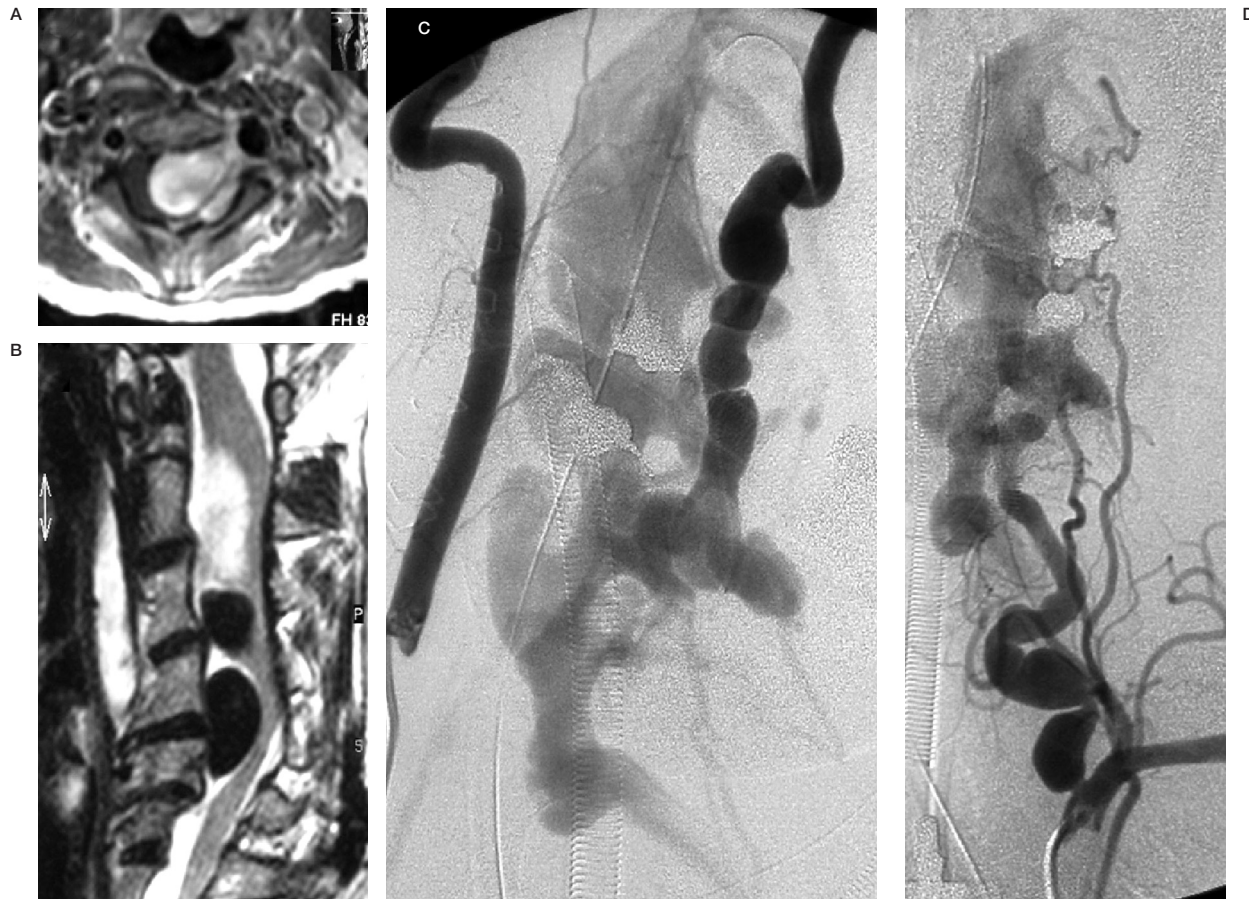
Case 1. A) Sagittal T2-W MRI (A) revealing large flow void epidural structures at C2-5, compatible with venous pouches and a partially thrombosed superior portion, causing severe cord compression. B) Axial T1-W MRI post Gd enhancement showing extension of the epidural venous pouches along the left neural foramen with nerve root compressions. C,D) Right and left vertebral angiograms demonstrating AV shunting from the LVA at C4 level, compatible with VVAVF. Dysplastic change and tortuosity of the LVA proximal and distal to the fistula are also noted with indirect collaterals from the left ascending cervical artery and thyrocervical trunk due to a “sump effect”.
